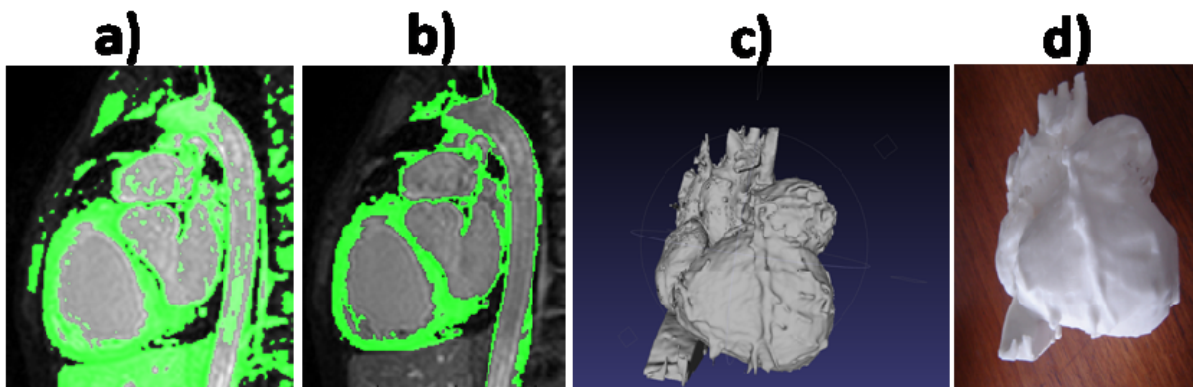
(a) image segmentation of a cardiac MRI based on thresholds. (b) The amount of spurious segmented pixels can be reduced using Active Contours. (c) The proposed triangulation methods allows us to reconstruct smooth renders of the heart, and it allows us to print a realistic replica of the heart using RP technologies (d).
